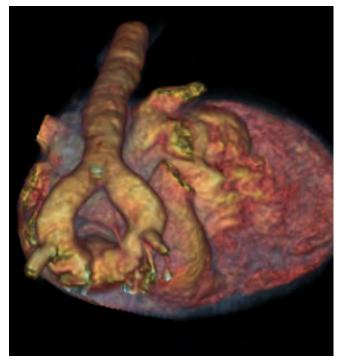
CT-angiography. The double aortic arch forming the complete vascular ring can be clearly observed here.
